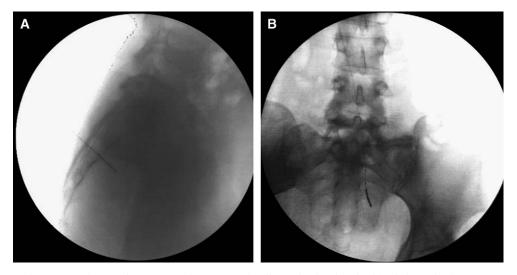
Lateral (A) and anteroposterior (B) sacral radiographs showing tined lead electrode placement.
